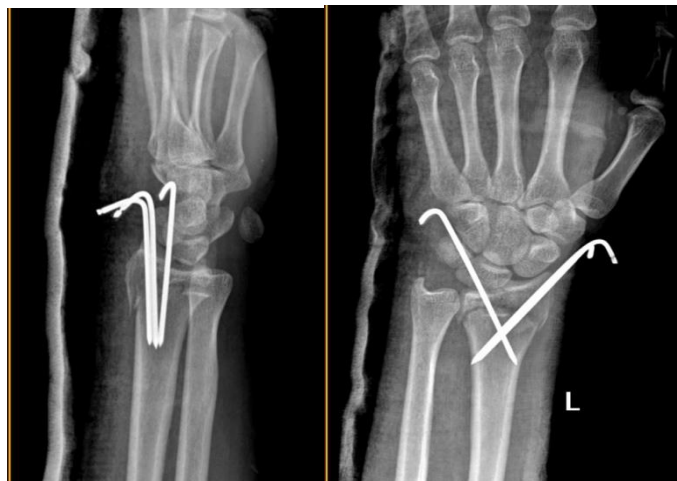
Post-op x-ray AP & lateral view
